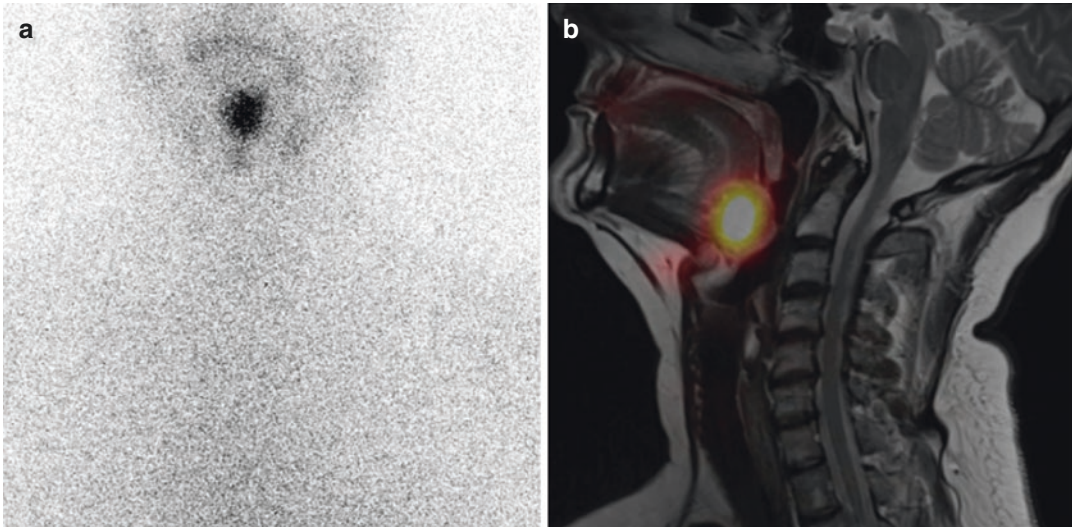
$^{123}\text{I}^-$ imaging; (a) planar image from anterior, (b) SPECT+MRI fusion image showing intense iodine uptake to a benign lingual struma in a 49-year-old patient presenting with swallowing complaints (after having
